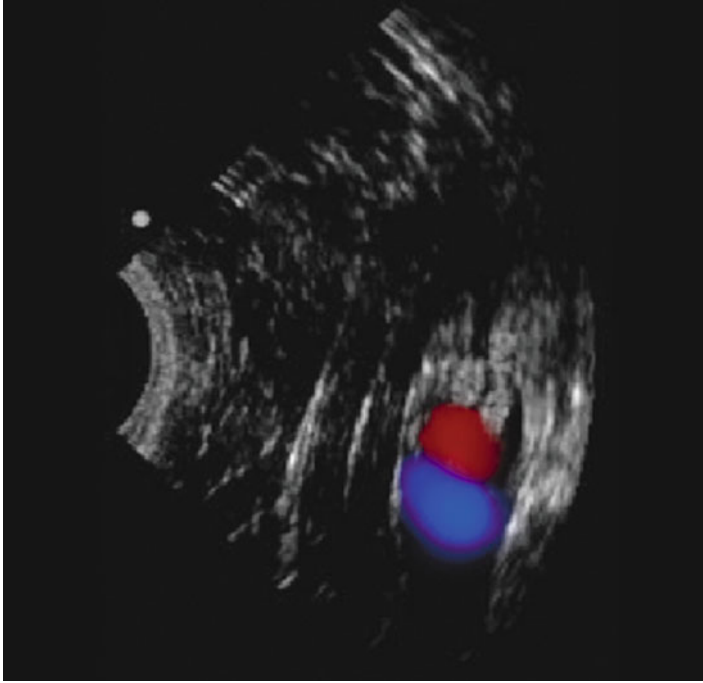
Color flow Doppler Image. *Blue*: flow away from the probe and *red*: flow toward the probe
